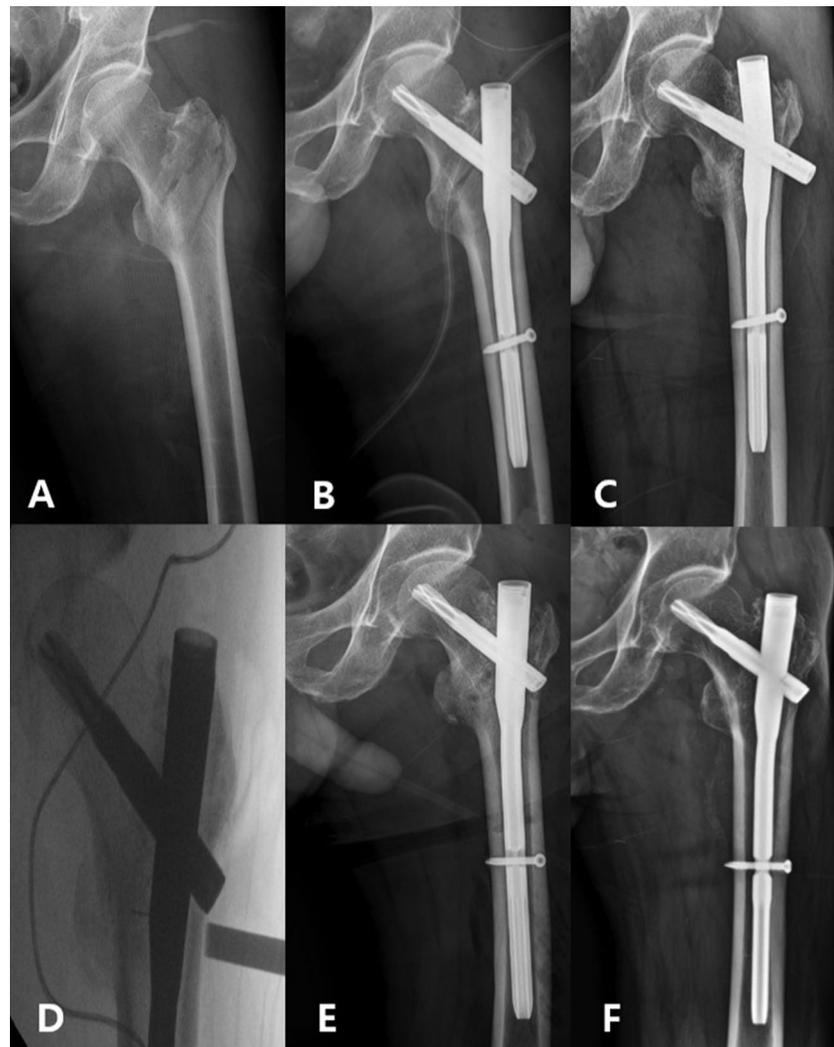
Pelvis anteroposterior radiographs of an intertrochanteric fracture in a male patient in his 70s. (a) Preoperative radiographs show an intertrochanteric fracture (Arbeitsgemeinschaft für Osteosynthesefragen/Orthopedic Trauma Association 31-A2.1). (b) Immediate postoperative radiograph after fixation using proximal femoral nail antirotation showing a fracture gap. (c) The nail broke at the proximal aperture 6.9 months later due to nonunion. Fracture gap is persistent although compared to the immediate post-operation radiograph. (d) Using a chisel we performed a small osteotomy just below the sleeve of the helical blade on the lateral side. (e) The long proximal femoral nail antirotation with lateral notching and dynamization was performed after proximal femoral nail antirotation removal. (f) The radiograph taken 19.8 months after salvage surgery shows no gap, indicating that there is good bone contact, and the fracture has healed
